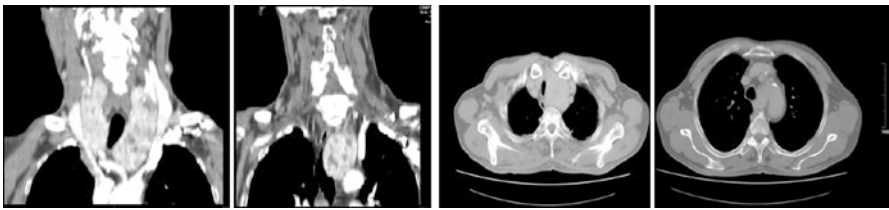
Neck and chest CT with and without contrast: cervico-mediastinal goiter. It is observed inhomogeneous and enlarged thyroid gland that takes advantage in the mediastinum with lateral deviation of the trachea to the right which is partly compressed
